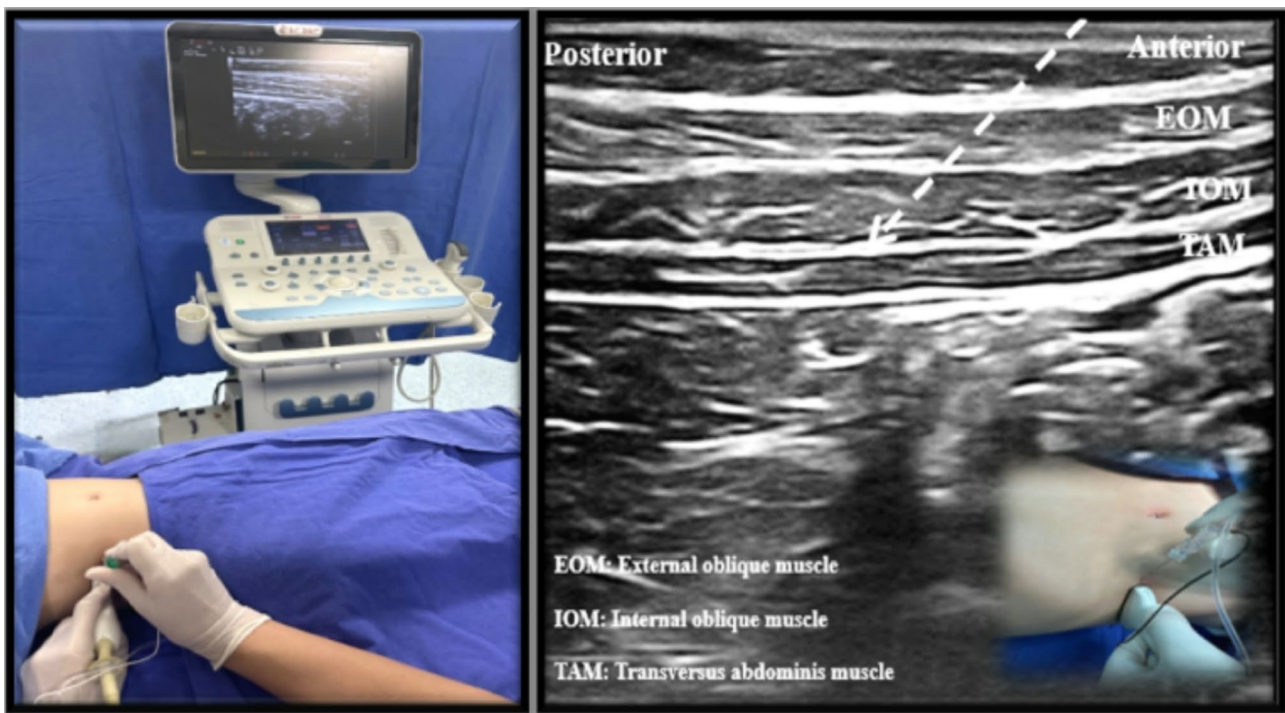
Application of the TAP block and an ultrasound image
